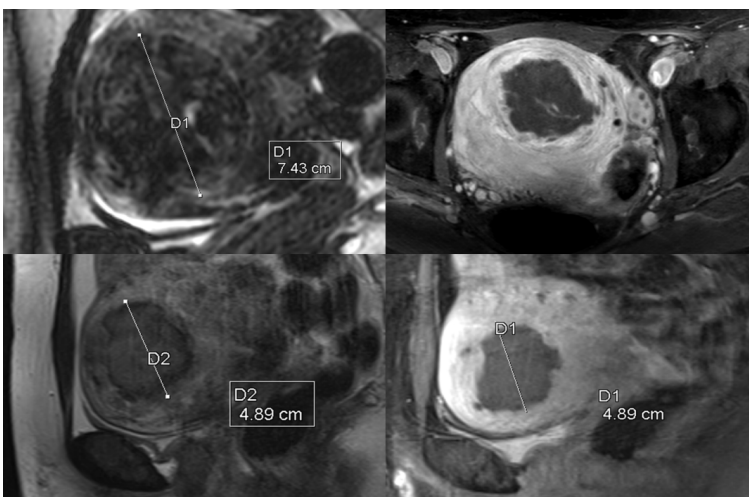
Diagnostic T2-weighted- and contrast-enhanced- MR- images before, immediately and 6 months after MR-HIFU of a 39-year-old patient with a big intramural fibroid and hyper-/ dysmenorrhea. Volume reduction and complete absence of symptoms 6 months after HIFU treatment was achieved, although the fibroid was not to 100% ablated (71% NPV).
